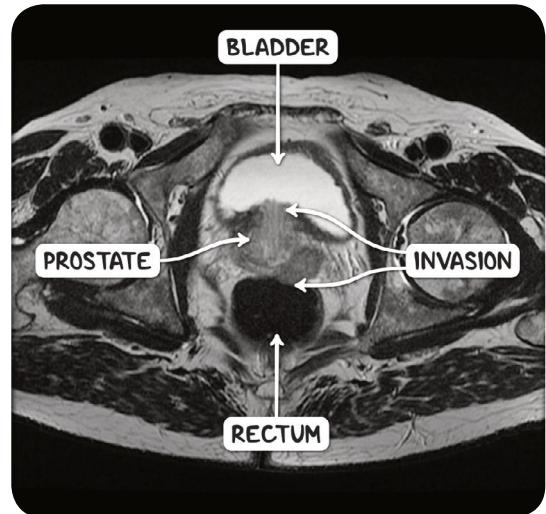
An MRI scan of the pelvis in the axial plane demonstrating prostate adenocarcinoma invading the bladder and the rectum.
